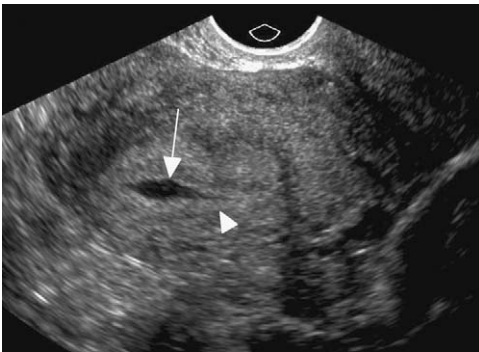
Pseudosac in the setting of ectopic pregnancy. Sagittal transvaginal ultrasound of the uterus shows an elongated fluid collection (arrow) located centrally within the cavity. It is surrounded by a single, echogenic layer (arrowhead) of endometrium. An ectopic pregnancy (not shown) was identified in the right adnexa.
